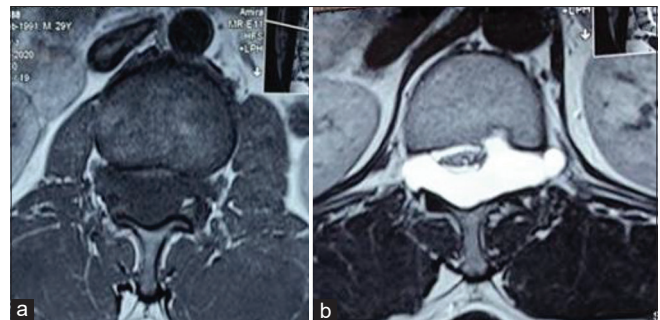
MRI of the dorsolumbar spine, axial section T1WI (a) and T2WI (b), demonstrates that intensity is similar to that of CSF which is isointense in T1WI and hyperintense in T2WI.
